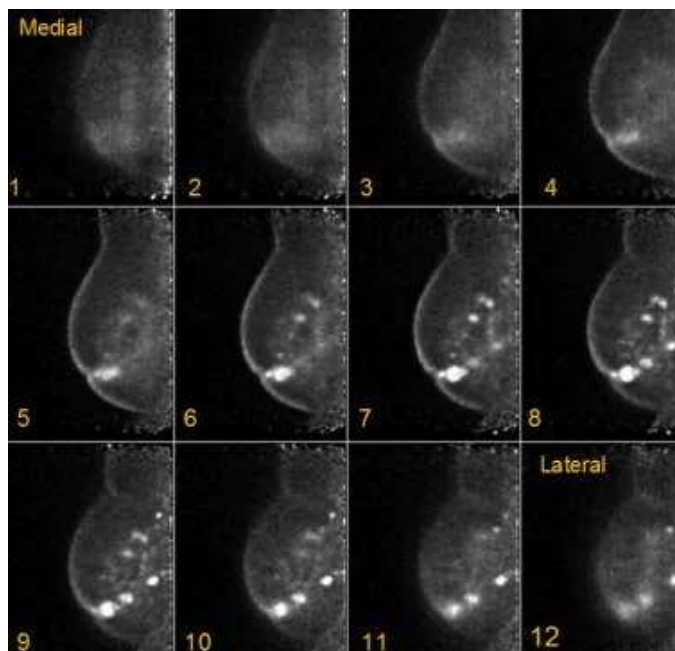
Grade III multifocal infiltrating ductal carcinoma as seen on F-18 fluorodeoxyglucose positron emission tomography . This organ specific positron imaging technique results in a much higher resolution (down to 1 to 2 mm) compared to whole body PET/CT imaging (17)
